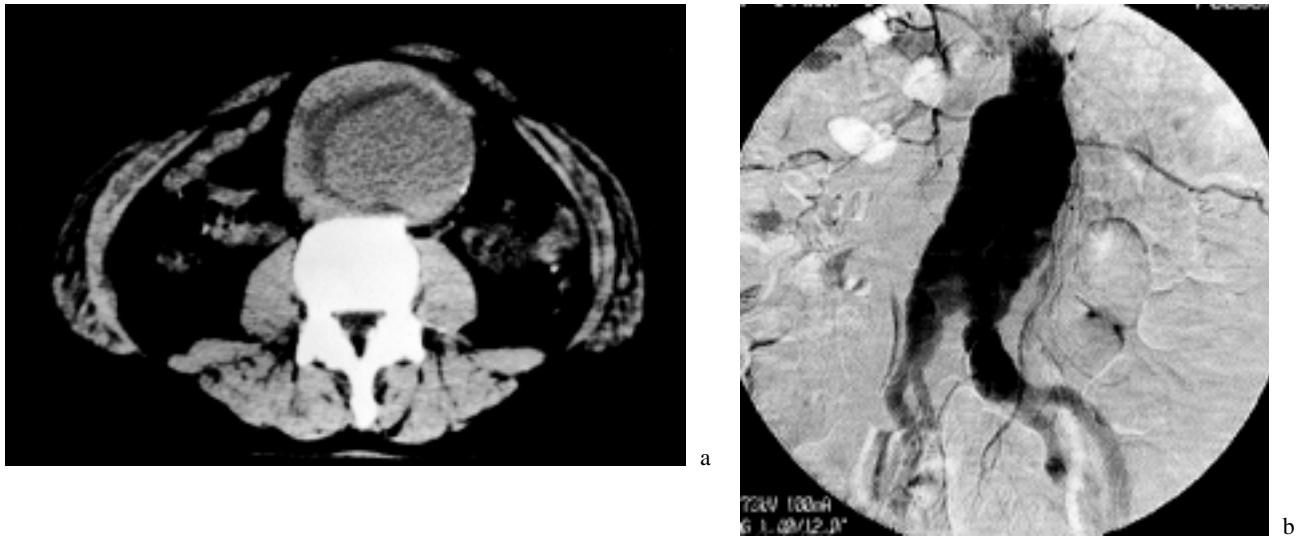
Aortogram (a) and computed tomography (CT) (b) in case 1. CT reveals a 9-cm AAA.
